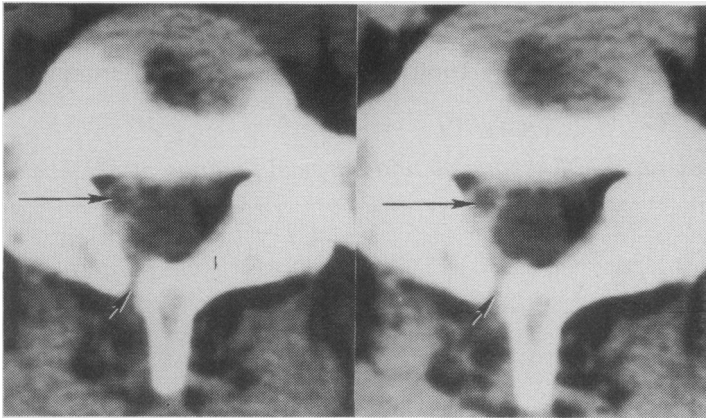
(a) and (b). Pure epidural fibrosis. CT scans before (a) and after (b) intravenous contrast. Non-enhancing nerve root (long arrow) is surrounded by enhancing fibrosis. Note enhancing tissue extending along margin of thecal sac to laminectomy scar (short arrow).
